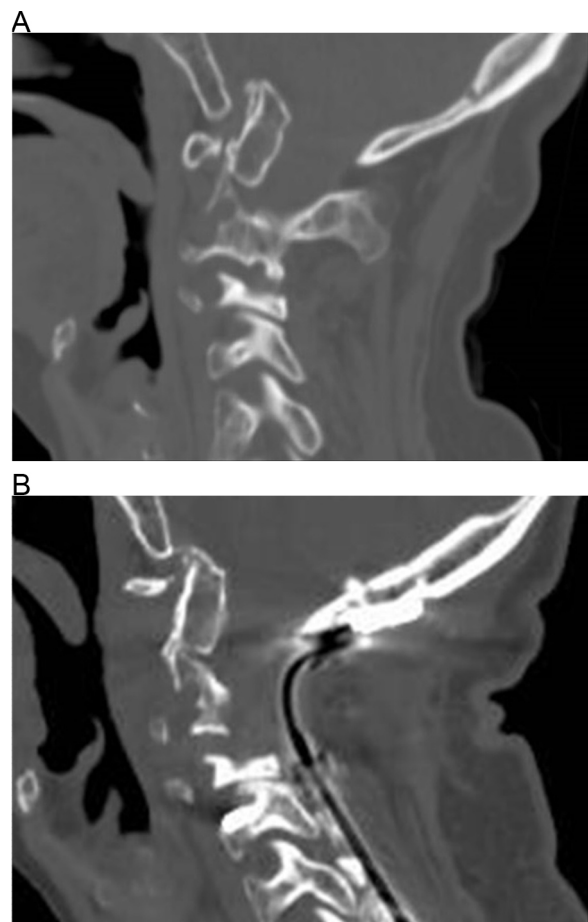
(A) Preoperative sagittal cervical CT shows basilar invagination and CVJ kyphosis. The clivoaxial angle was 131° . (B) Postoperative sagittal cervical CT shows the improvement of the basilar invagination and CVJ kyphosis. The clivoaxial angle was 151° .
